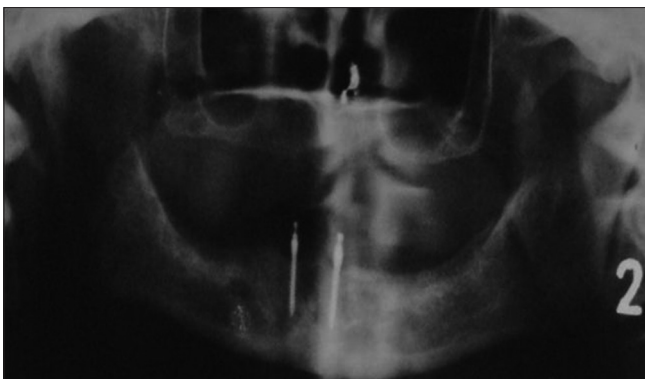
Orthopantomogram showing two mini implants placed in B and D position
